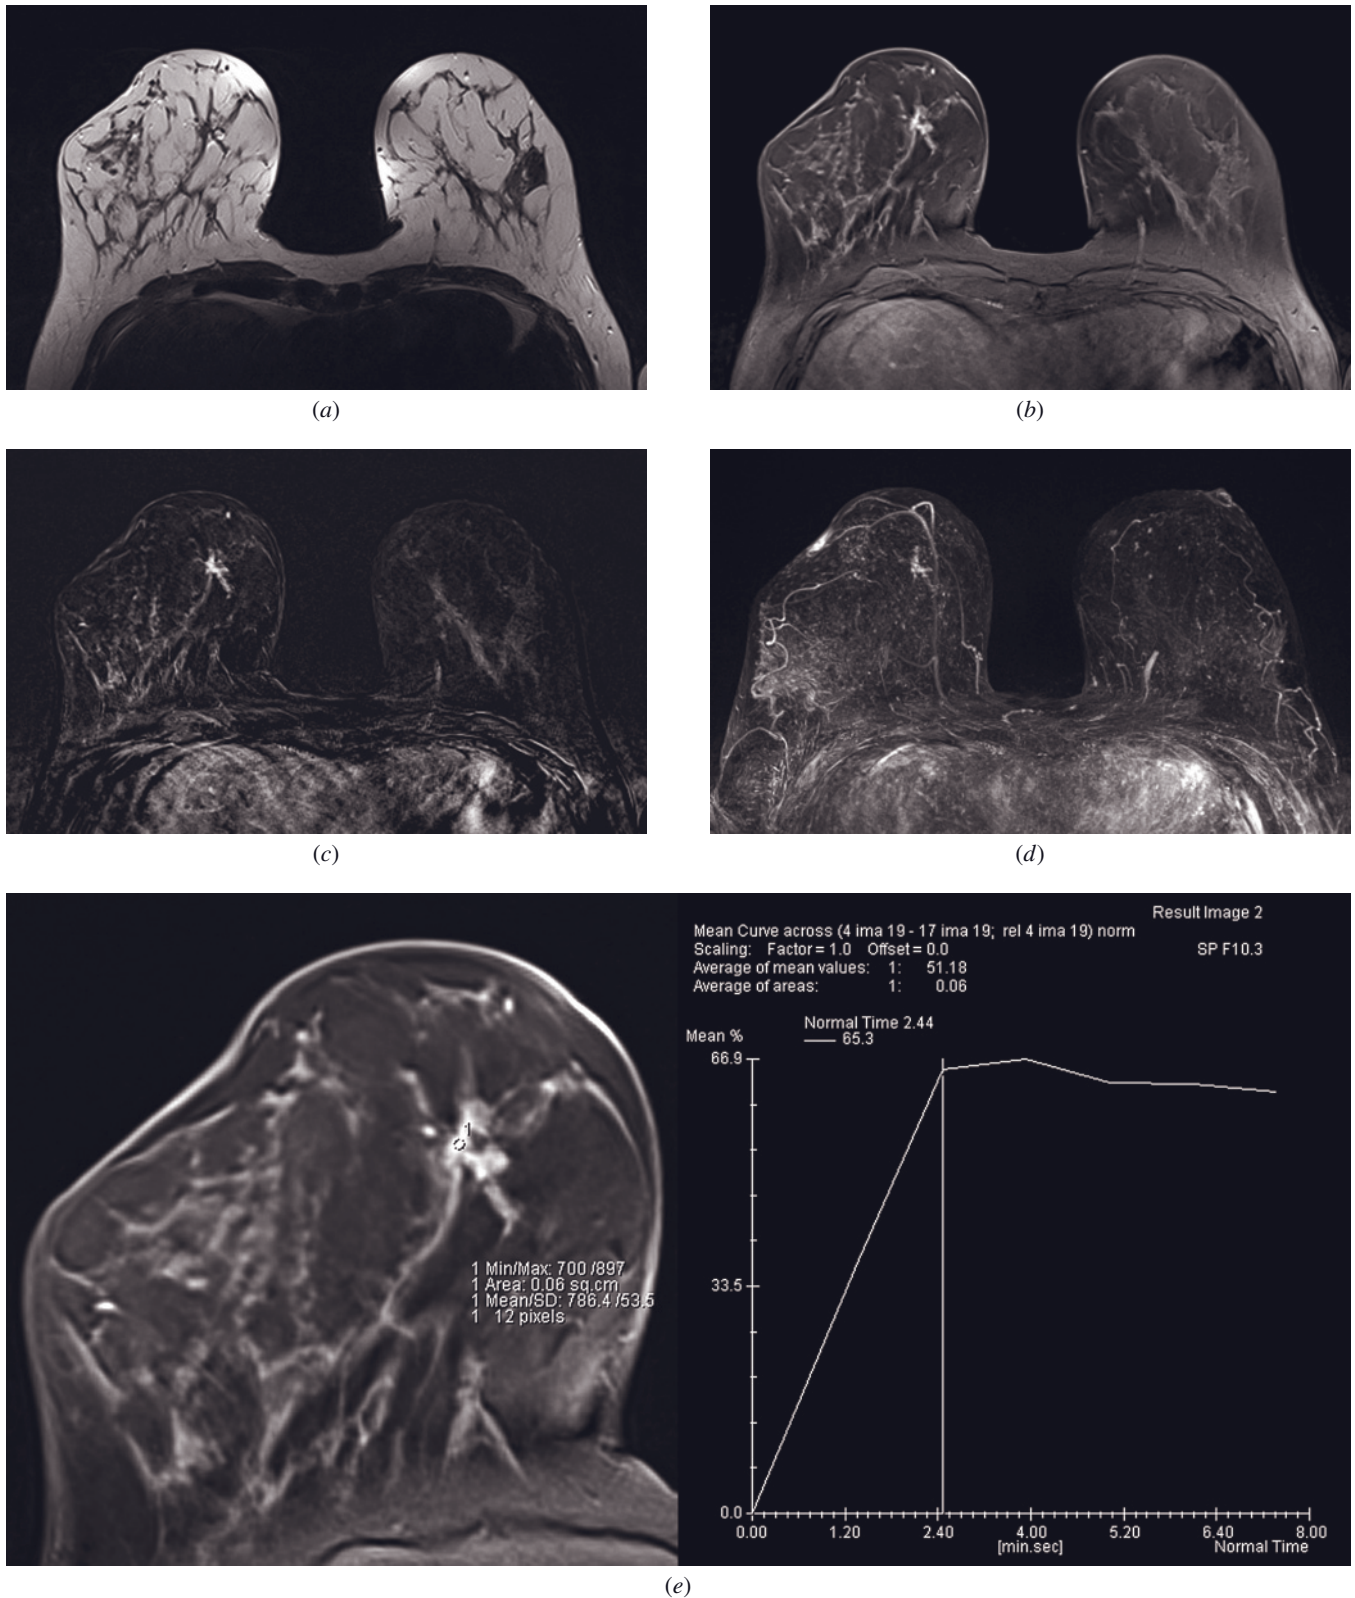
Radial scar. Axial T2-weighted image (a) reveals a hypointense spiculated lesion in the right breast showing enhancement on postcontrast GRE (b), subtracted (c), and MIP images (d) with morphology that is indistinguishable from carcinoma. However, the dynamic curve (e) demonstrates a plateau pattern (Type II) with moderate initial enhancement and maximum signal increase of 67% at 4 min after administration of GBCA. The moderate enhancement rate in the first 2 min categorizes this lesion as a BI-RADS 4 despite its morphology. Excisional biopsy revealed a radial scar.
